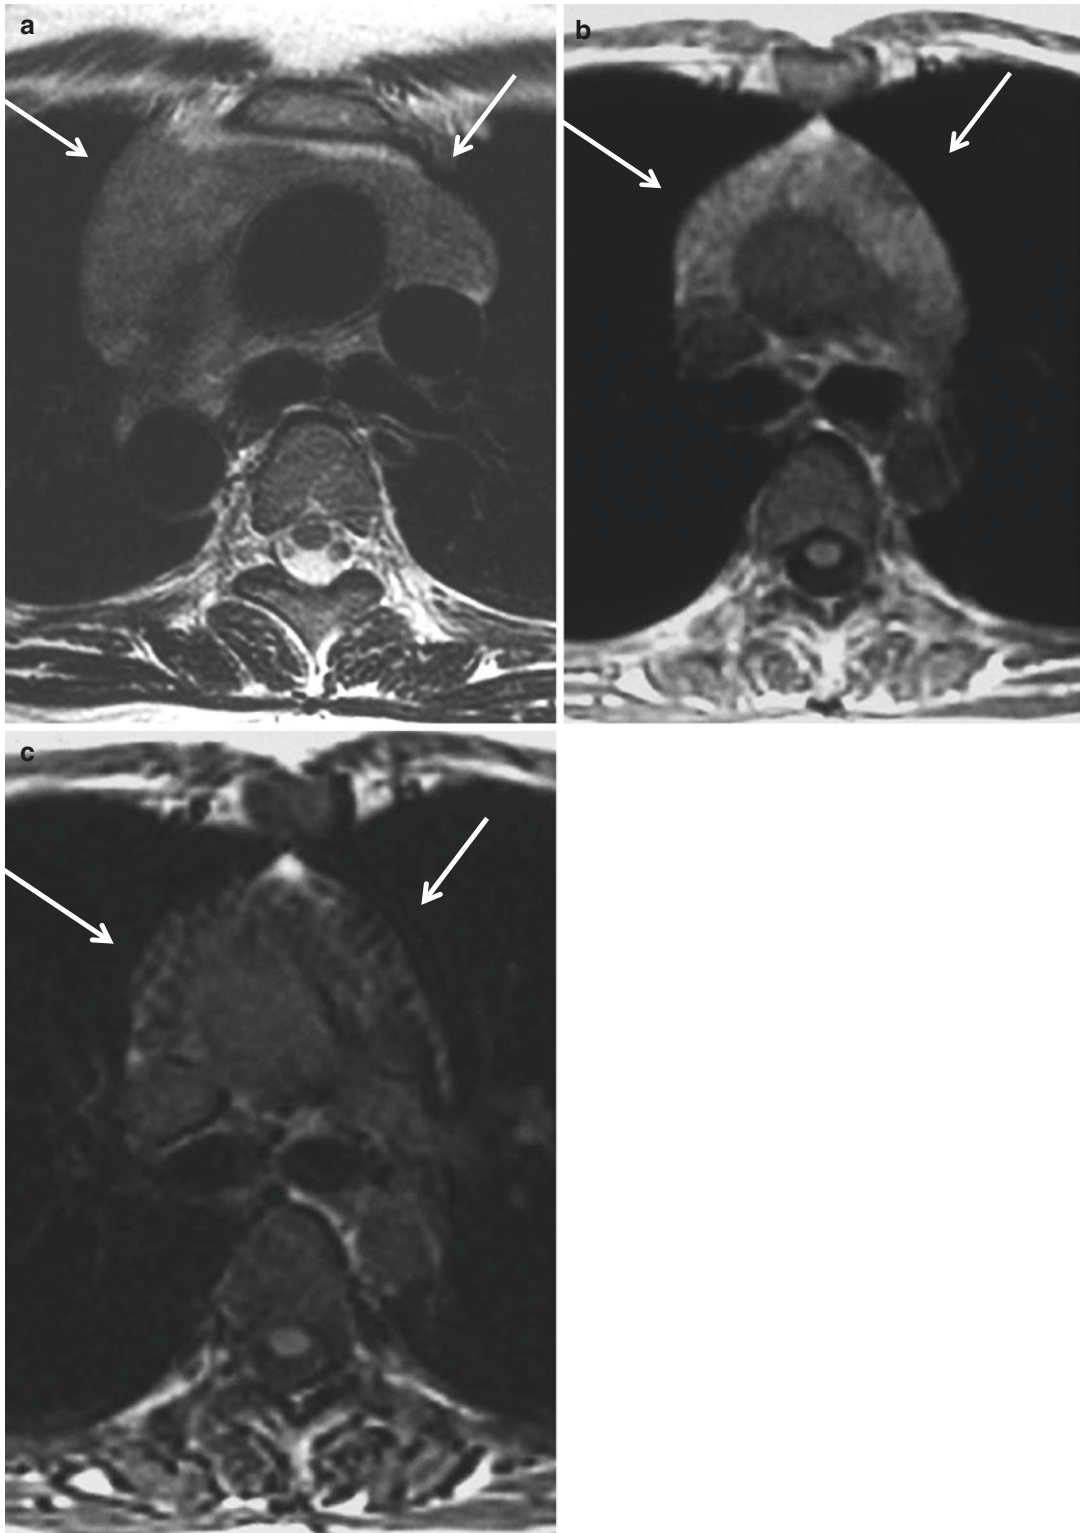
Thymic hyperplasia in hyperthyroidism in a 25-year-old woman. T2-weighted (a) and in-phase (b) and opposed-phase (c) gradient-echo T1-weighted MR images. The thymus is diffusely enlarged but shows a
